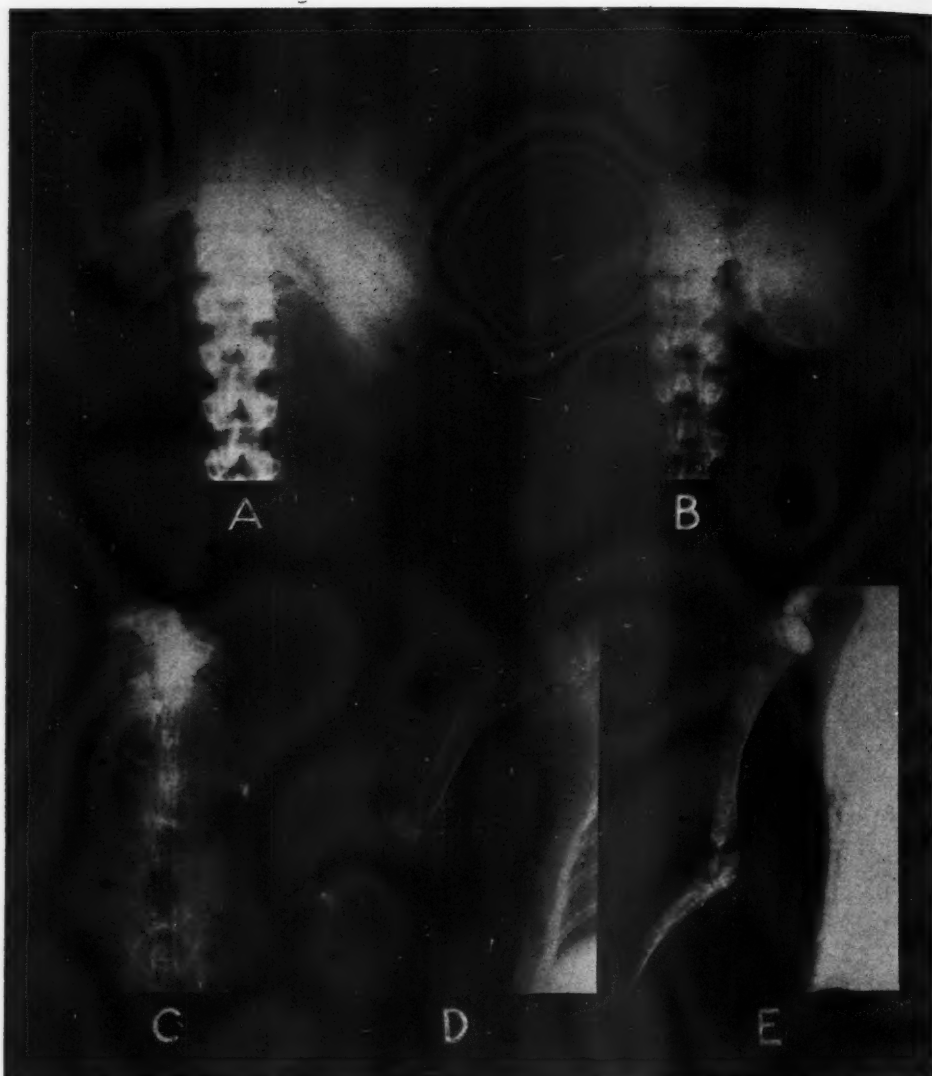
Roentgenogram of a patient taken 24 hours after intravenous injection of 75 c.c. thorium dioxide sol.
